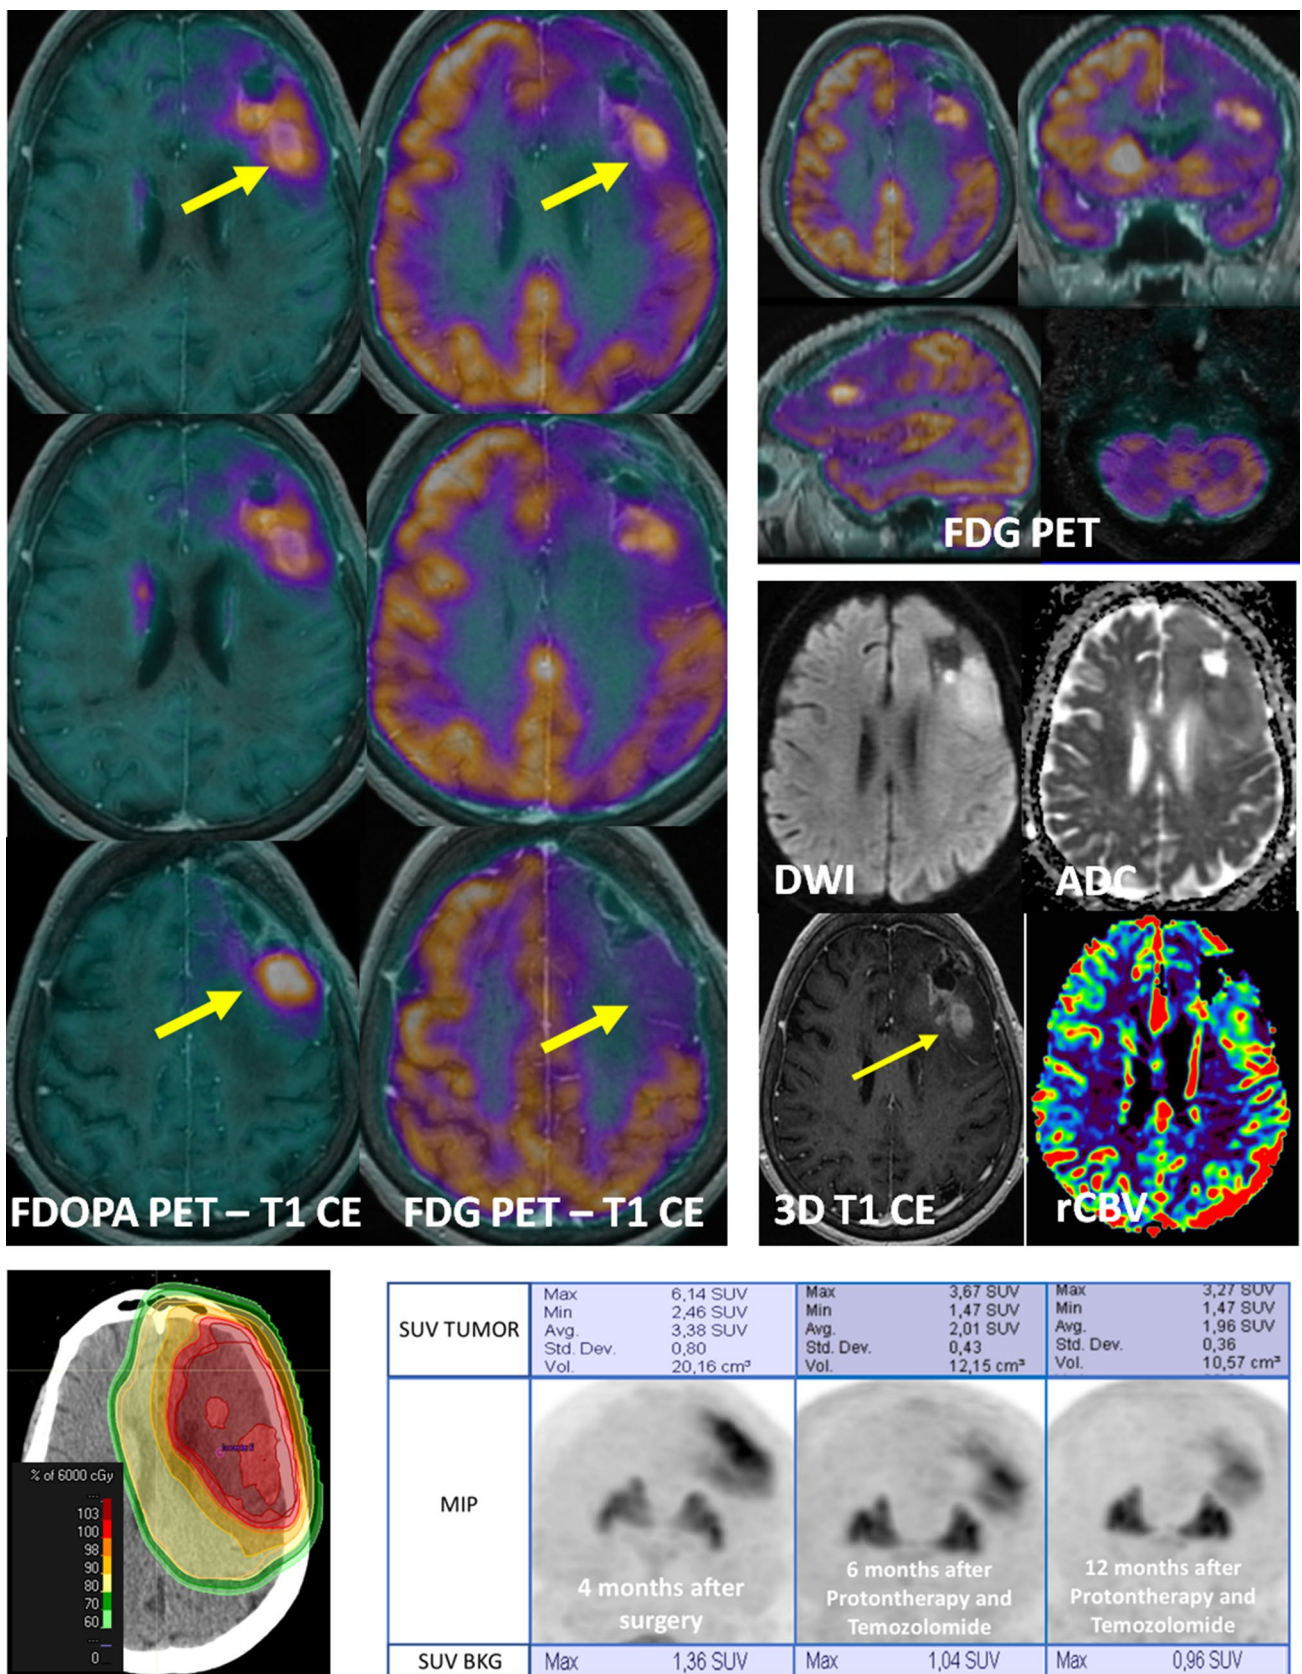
FDG and FDOPA PET assessment of disease progression from LGG to HGG after surgery and F-DOPA-PET monitoring response to chemotherapy and radiotherapy
